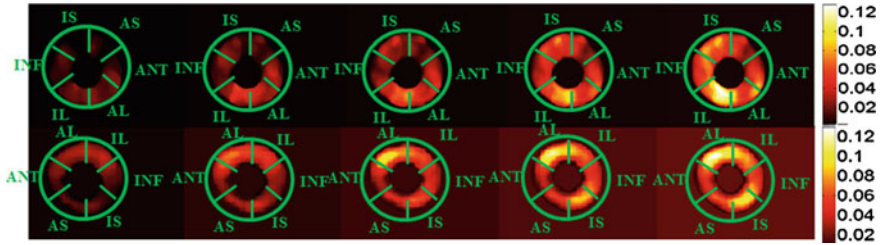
Top row* Lagrangian radial strain maps computed from TDIOF. *Lower row* Lagrangian radial strain maps computed with SinMod from tagged MRI during the same cardiac phase at the high papillary muscle level in one subject (AS antero-septal, ANT anterior, IL infero-lateral, AL antero-lateral, P posterior, INF inferior, IS infero-septal). The tagged MR images are resized to match the echo images with respect to the size
